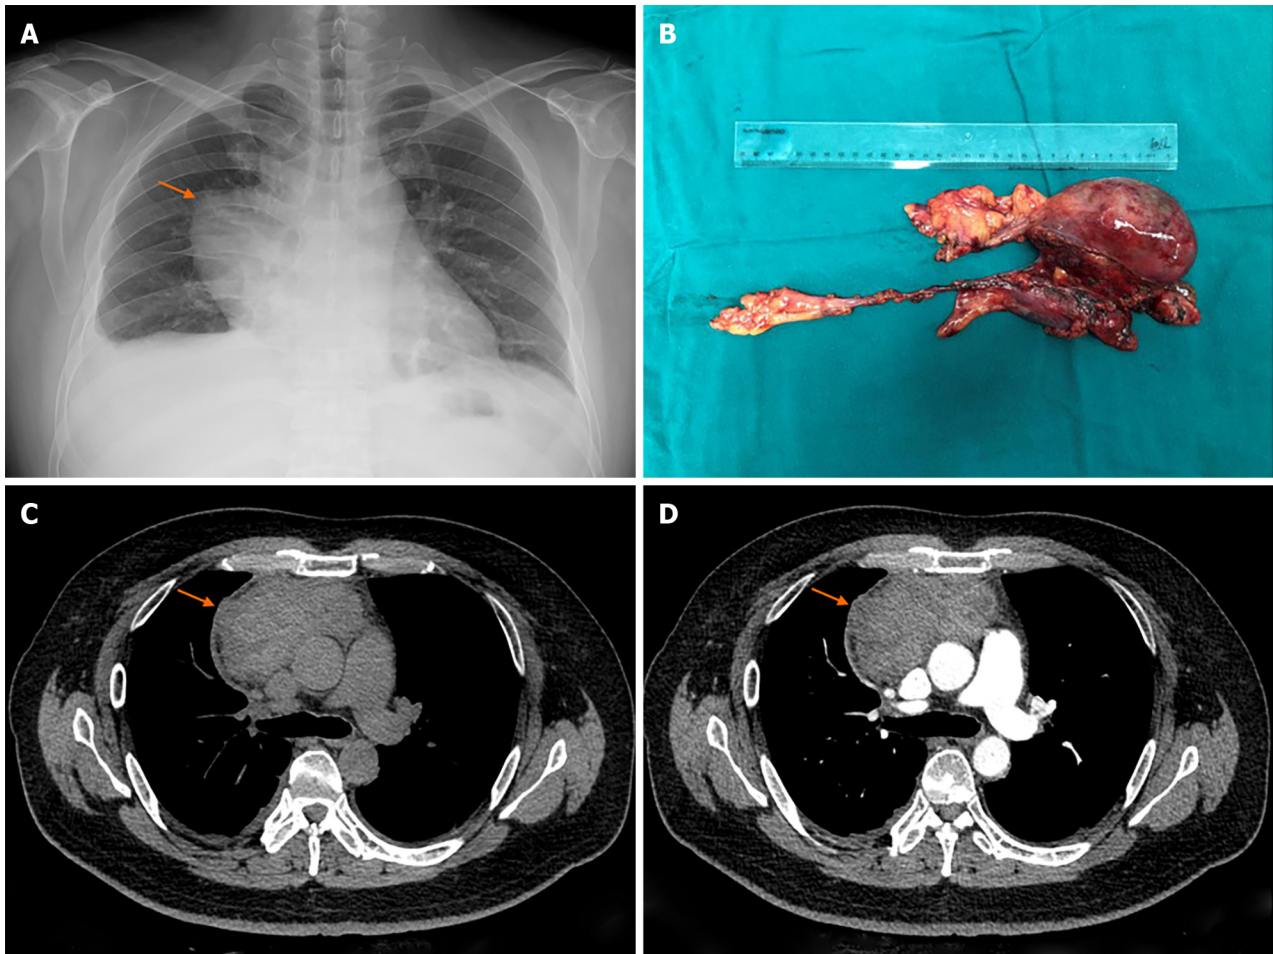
Radiology and macroscopic pathological image. A: Chest X ray image; B: Macroscopic pathological image; C: Plain computer tomography (CT) image; D: CT image after contrast agent injection.
